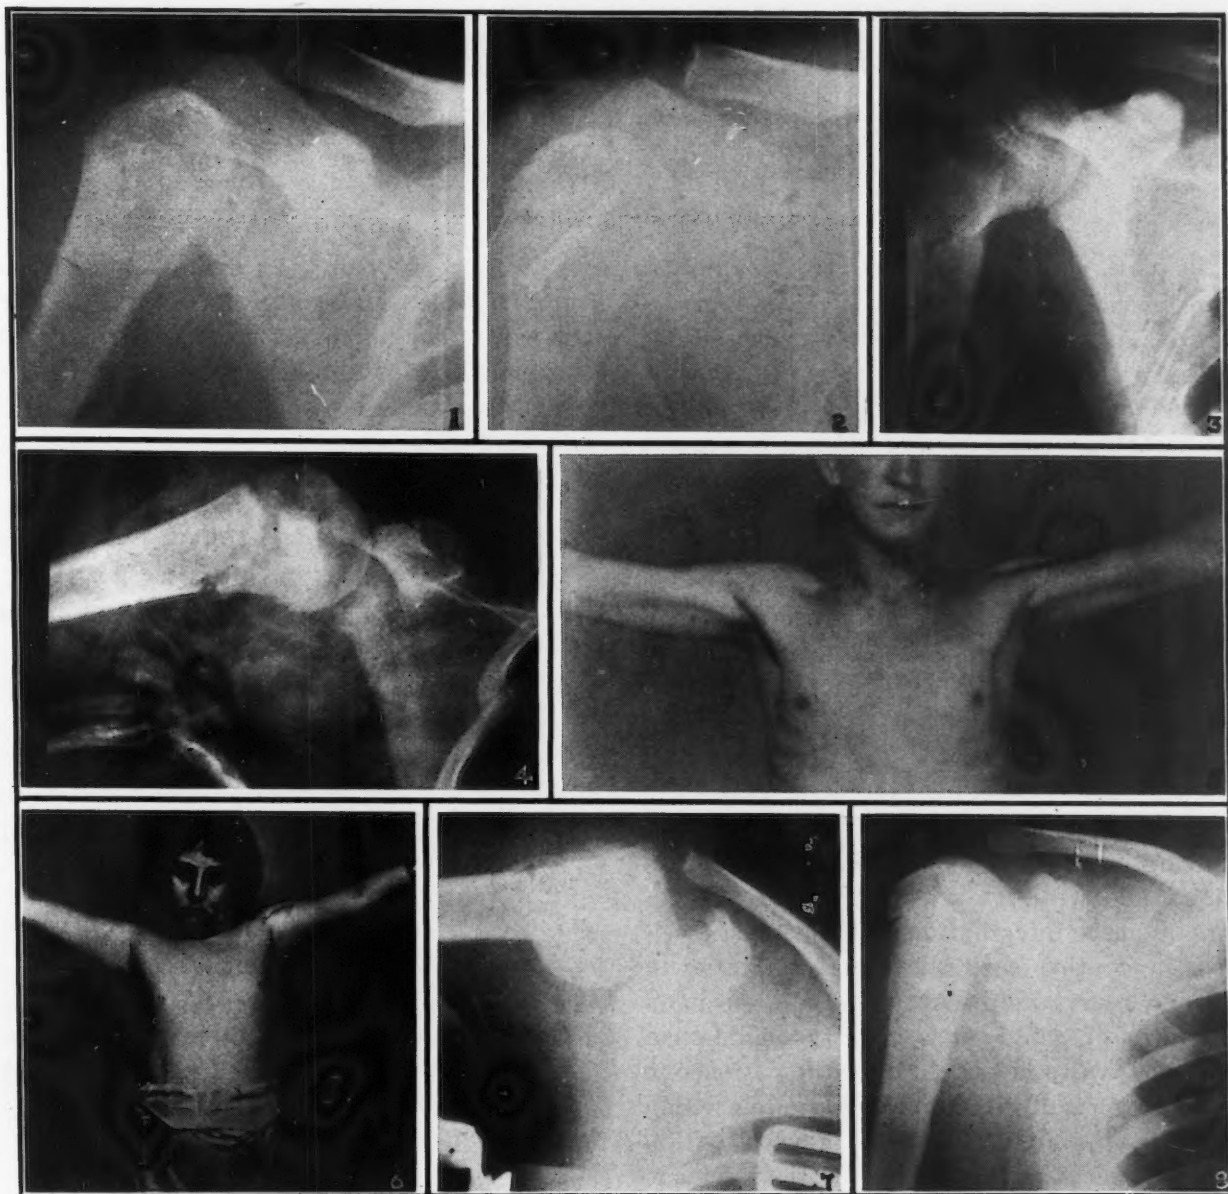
Case 1.—X-ray before operation. Fig. 2. Case 1.—X-ray after fixation. Fig. 3. Case 2.—X-ray before operation. Fig. 4. Case 2.—X-ray after operation. Fig. 5. Case 2.—Recent photograph. Fig. 6. Case 4.—Recent photograph. Fig. 7. Case 3.—X-ray before operation. Fig. 8. Case 3.—X-ray after operation.
